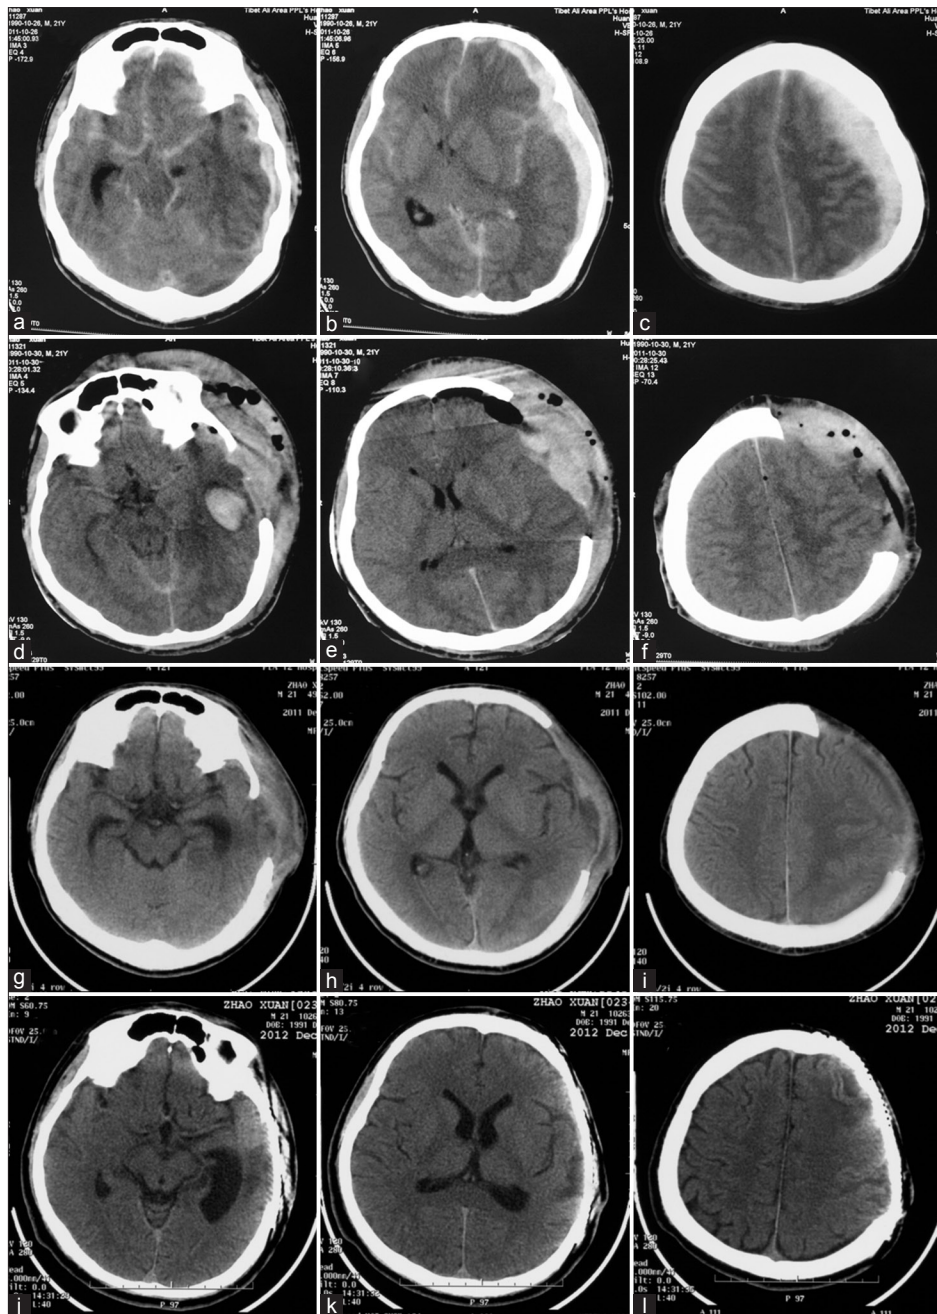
Craniocerebral computed tomography (CT) of the patient. (a-c) Preoperative CT scan indicated a large acute subdural hematoma in the left fronto-temporo-parietal region, widespread subarachnoid hemorrhage and brain herniation; (d-f) CT scan on postoperative day 2 disclosed that the subdural hematoma and subarachnoid hemorrhage almost disappeared, although a small intracerebral hematoma occurred in the left temporal lobe; (g-i) CT scan at postoperative one and a half months showed that the small intracerebral hematoma in the left temporal lobe had been absorbed; (j-l) CT scan at 5 months after cranioplasty indicated the cranial appearance was good.
